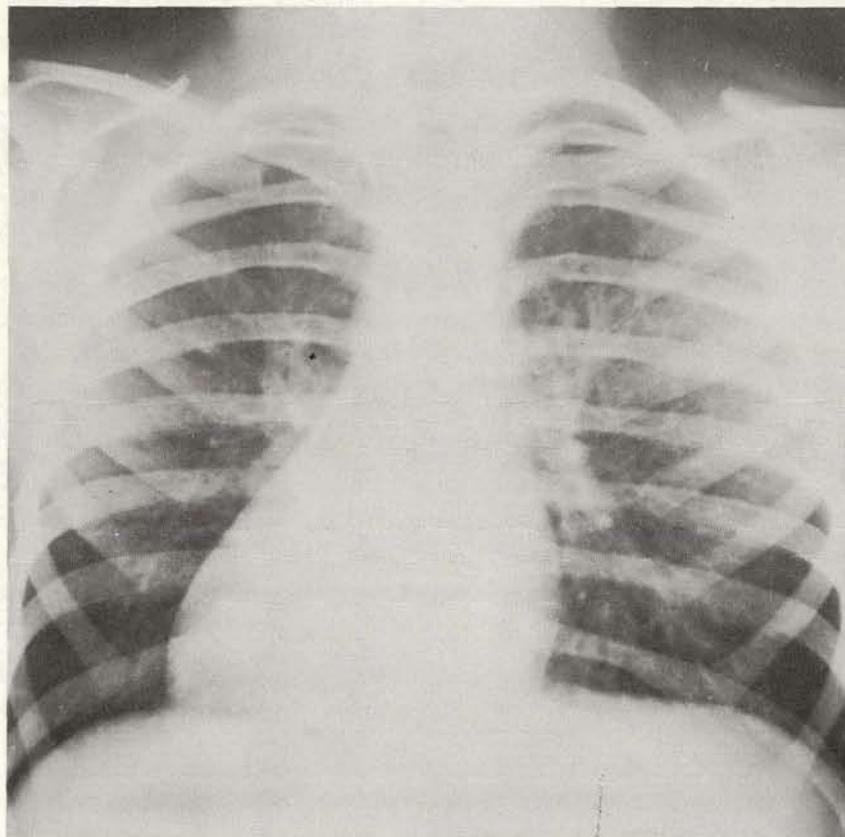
Roentgenograph of chest after treatment with I^{131} . All the lesions had cleared roentgenographically.
